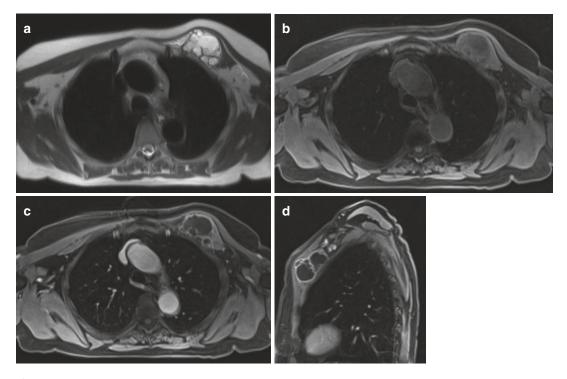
(a–d) Extraskeletal chondrosarcoma of the left pectoralis minor in 63-year-old female: (a) axial T2-weighted HASTE MR image; (b) axial FS T1-WI. (c) Axial and (d) sagittal FS T1-WI following administration of gadolinium contrast. T2-WI reveal the lobulated shape
